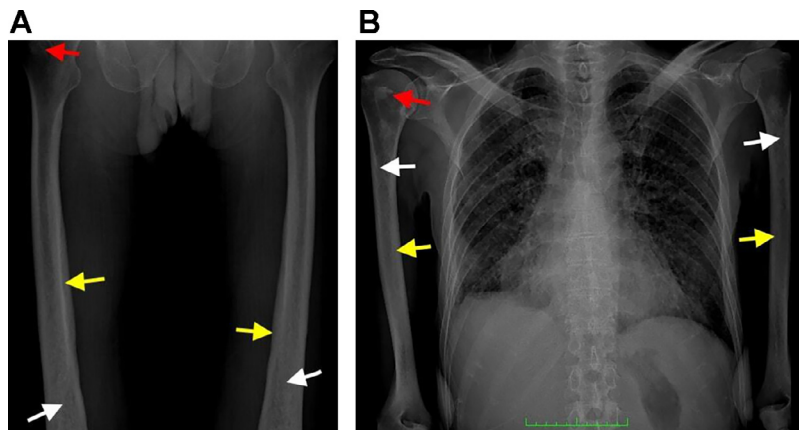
A 53-year-old male patient with Erdheim Chester disease. Frontal radiographs of both femurs (A) and both humeri (B) show bilateral and symmetrical metaphyseal-diaphyseal patchy medullary sclerosis (white arrow) with resultant mild loss of corticomedullary differentiation. There is cortical thickening of the femur (yellow arrow) and an osteocondensing lesion at the neck of the right femur and humerus (red arrow).
